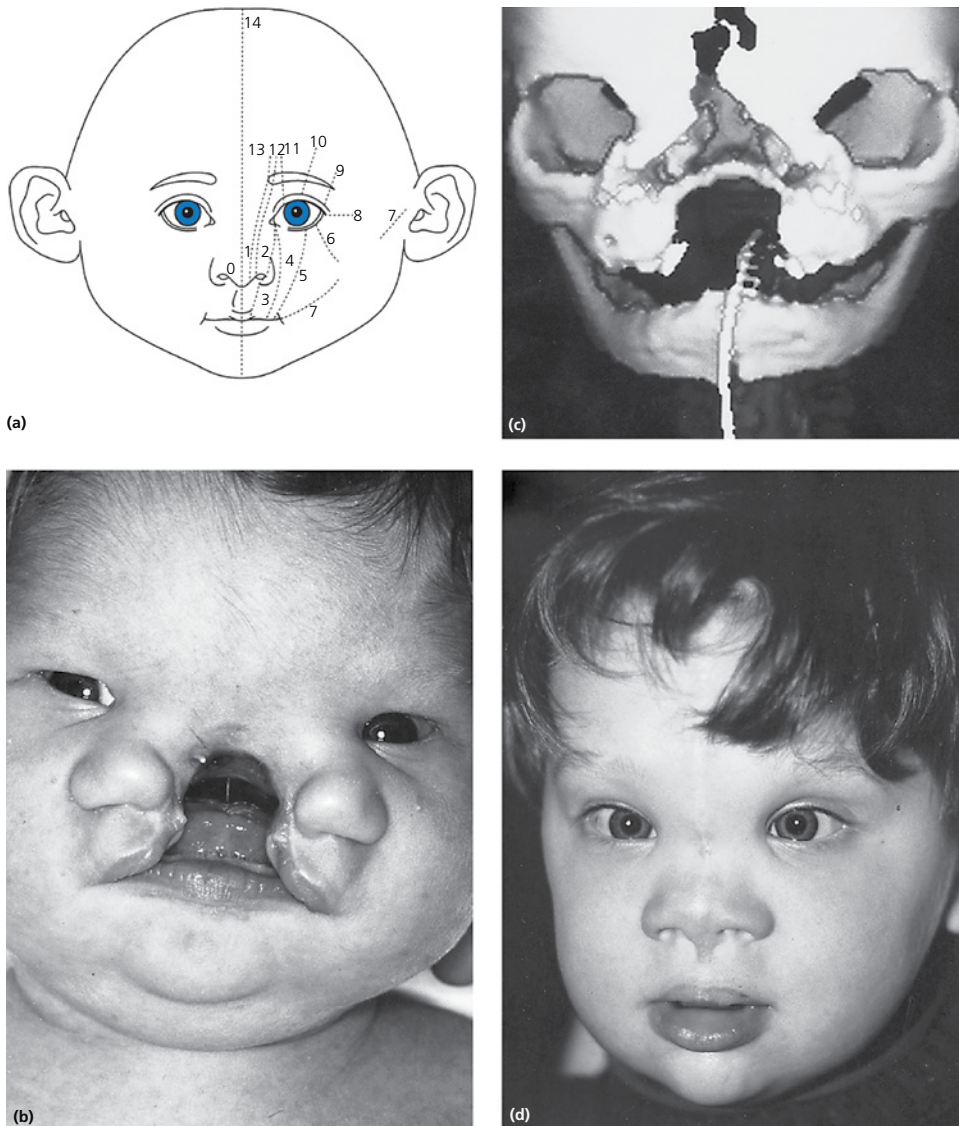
(a) The Tessier classification of craniofacial clefts. (b) A patient with a severe 0–14 midline Tessier cleft. (c) 3-D CT scan of the patient (with endotracheal tube *in situ*). The bony cleft continues in the 14 position and hypertelorism of the orbits is demonstrated. (d) Postoperative appearance after complete mobilisation of the orbits and maxillae with midline closure.
